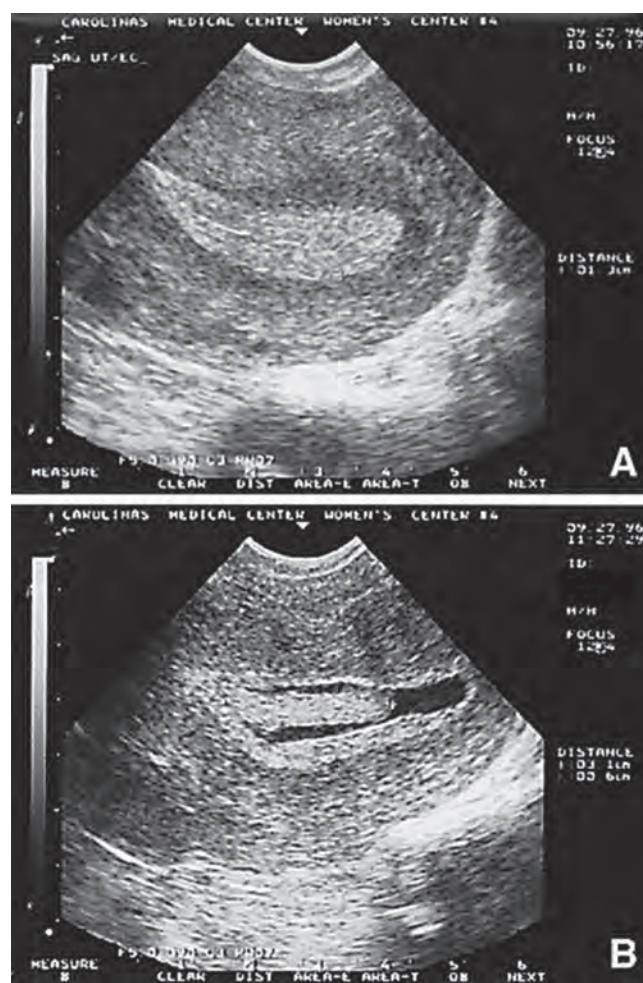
Example of a hydrososonogram used to detect and delineate an intracavitary lesion. (From Williams CD, Marshburn PB. A prospective study of transvaginal hydrososonography in the evaluation of abnormal uterine bleeding. *Am J Obstet Gynecol*. 1998;179:292–298.)
